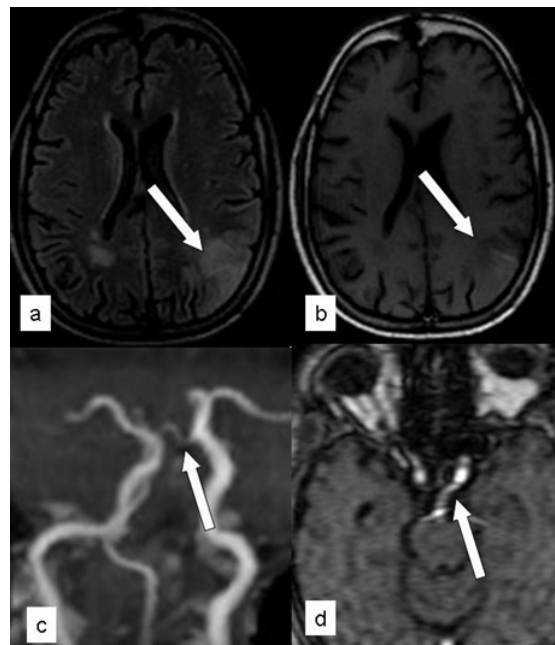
(a & b) Axial T2 FLAIR and T1 image shows infarct with hemorrhagic transformation in left parietal region. (C&d) MRA images show fetal origin of left PCA.
